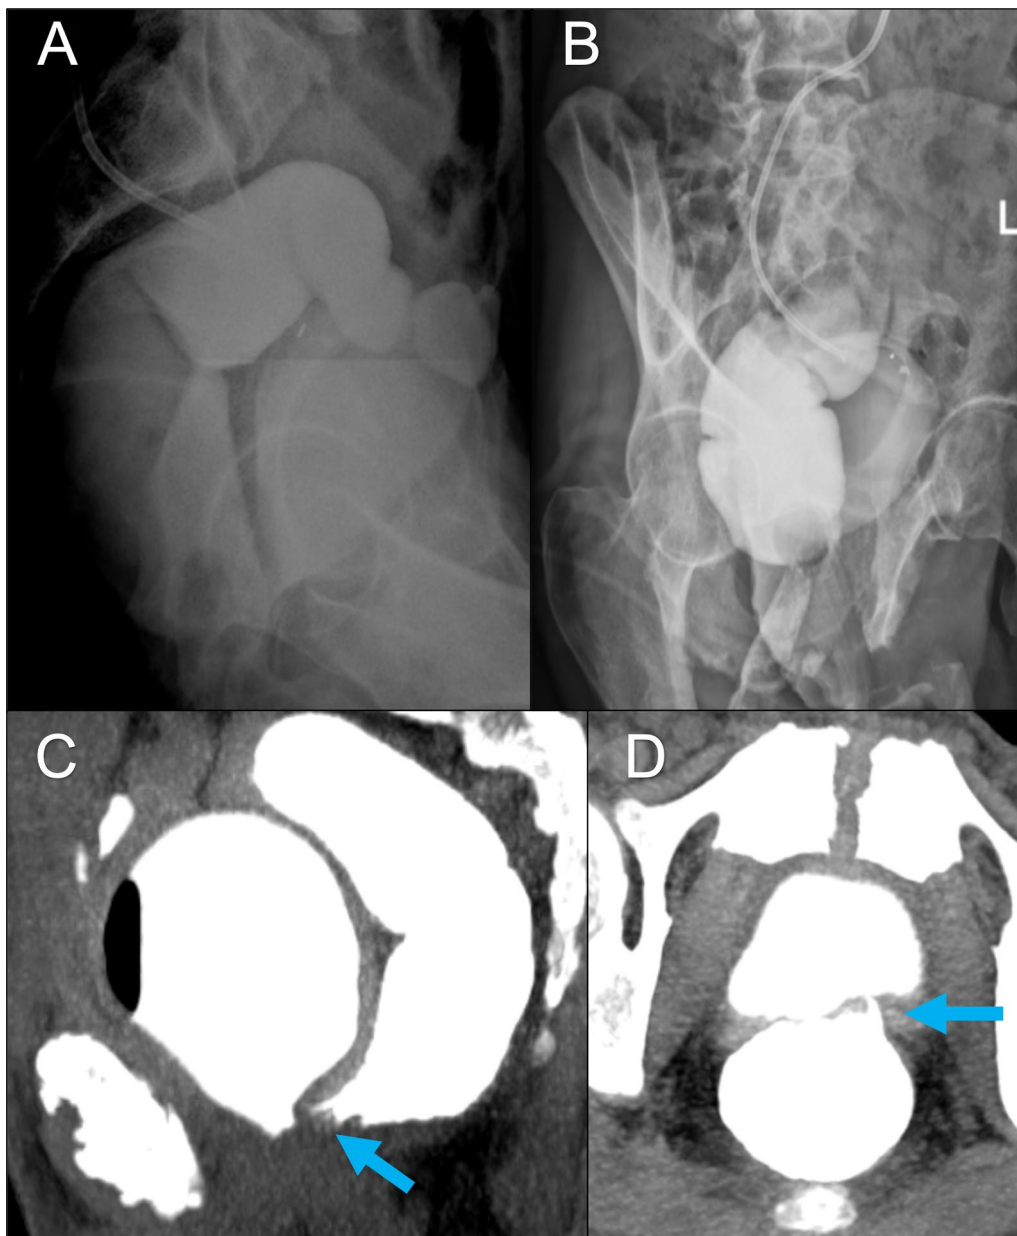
66-year-old male patient with history of colon cancer, underwent surgical resection and colostomy and received radiotherapy, presented with recurrent attacks of UTI, referred for assessment of the distal loop pre-stomal reversal, WSCE was performed followed by complimentary CT study. A and B Lateral and left oblique views of water-soluble contrast enema under fluoroscopic guidance showed opacification of the urinary bladder during administration of the rectal contrast. C and D Axial and sagittal CT study of the pelvis with MIP reconstruction after administration of water-soluble contrast enema revealed the presence of small fistulous communication (blue arrows) between the left aspect of bladder base and the lower rectum. Based on the imaging findings, the surgical management plan was fistulectomy and postponing the stoma reversal
